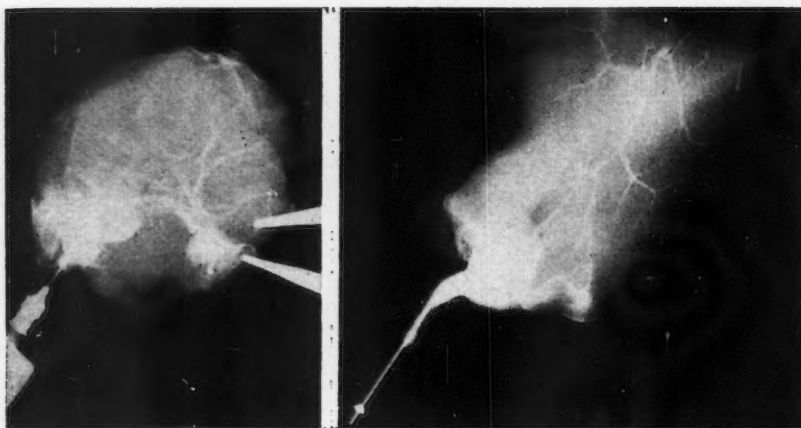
(a) Roentgenogram showing splenic artery implanted into kidney. Outline of kidney circulation made by injecting implanted splenic artery with radiopaque medium. (b) Roentgenogram showing splenic artery implanted into liver. Outline of liver circulation made by injecting radiopaque media through implanted internal mammary artery. (Photograph by courtesy of Davis.)
